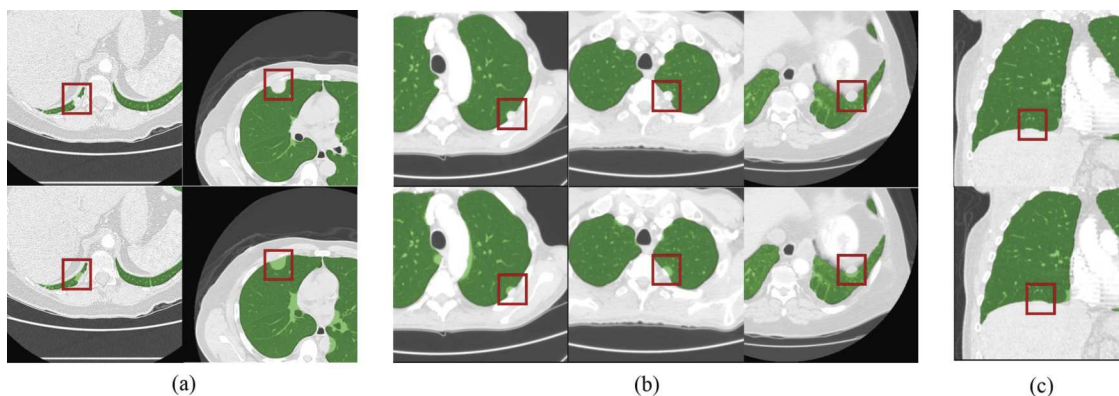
Examples of lung segmentation refinement outputs and its impact on nodule inclusion. First row shows CT slices with initial lung segmentation, for which lung nodules are excluded from the segmentation. Second row shows the corresponding CT slices with lung segmentation after refinement algorithm. All nodules are detected by the majority of radiologists and are indicated by red box in figures. (a) Example cases where nodules are included after refinement algorithm. (b) Example cases where nodules remain outside the lung segmentation, but are detected by the candidate detection. (c) Remaining case where nodule is neither detected by the candidate detection nor is inside the lung segmentation, as it has a flat morphology.
